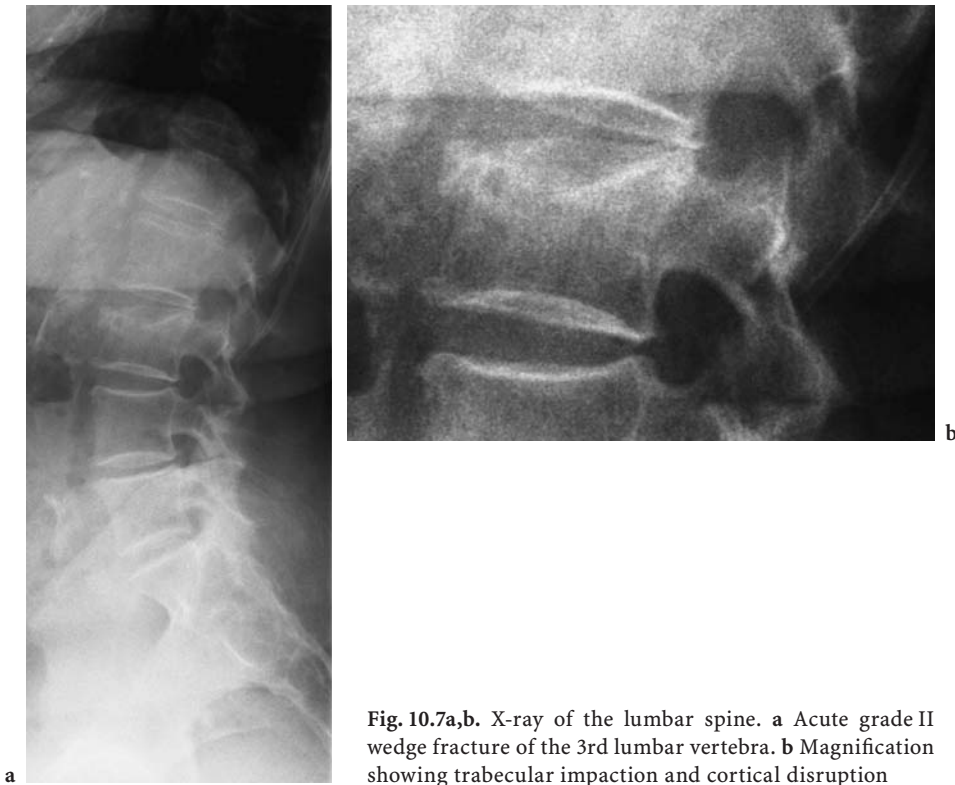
X-ray of the lumbar spine. a Acute grade II wedge fracture of the 3rd lumbar vertebra. b Magnification showing trabecular impaction and cortical disruption
